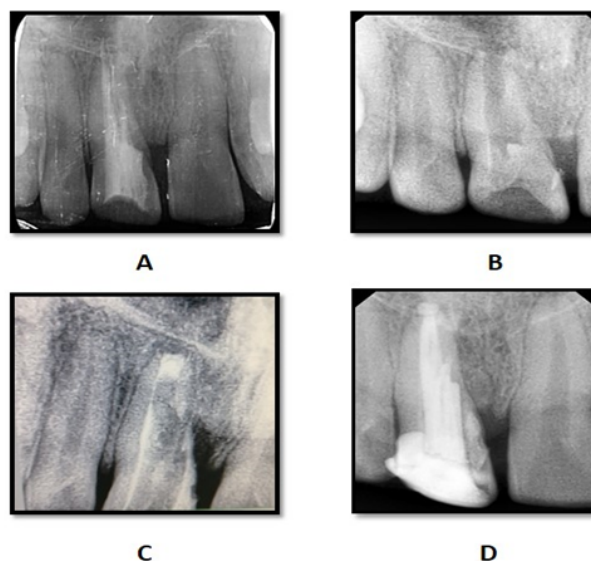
A: Pre-operative radiograph; B: Radiograph after removal of GP; C: Radiograph showing Placement of MTA on apex and lateral walls of canal; D: Radiograph showing obturation using rolled-cone technique
